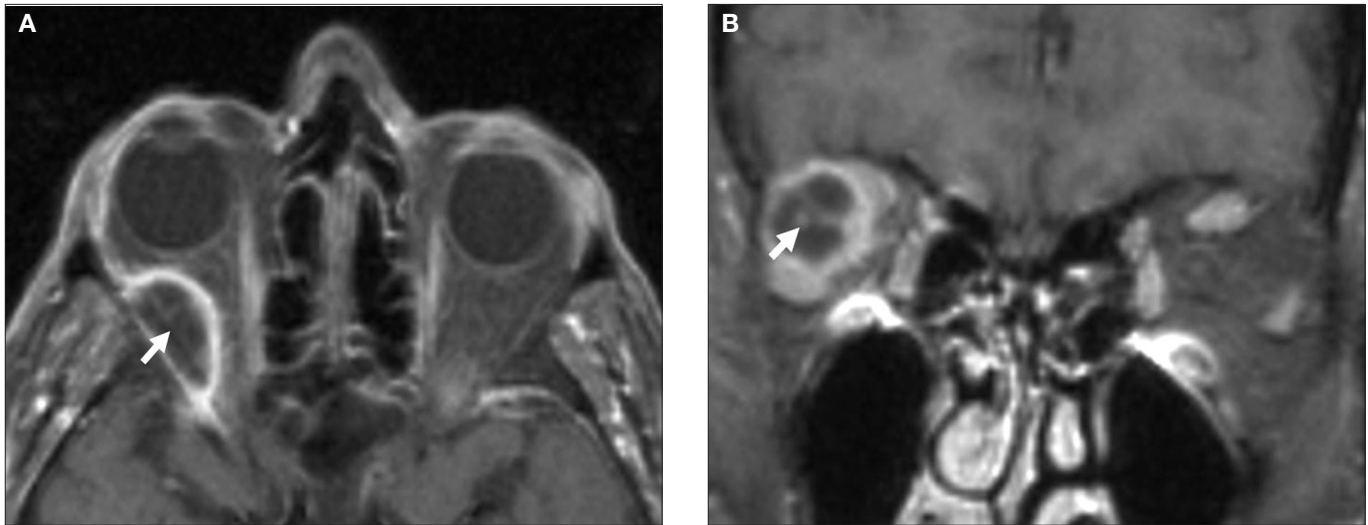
(A) T1-weighted, contrast enhanced, fat suppressed, axial magnetic resonance image (MRI) of the orbits confirming a well-defined cystic mass. A linear hyperintensity was seen running within the mass, which given the history of paraesthesia, was presumed to be the lacrimal nerve (arrow). (B) T1-weighted, contrast enhanced, fat suppressed, coronal MRI of the orbits reveals a hyperintensity in the center of the mass, corresponding to a nerve seen within the cyst intraoperatively.
